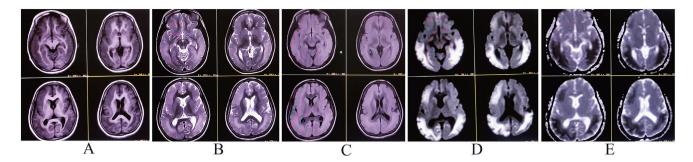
Thick band noted in the subcortical region of bilateral cerebral hemispheres, which is iso to gray matter in all sequences (A-T1, B-T2, C-T2-FLAIR), shows no contrast enhancement and is separated from cortical gray matter and ventricles by white matter—s/o subcortical band heterotropia. The overlying cortex shows broad gyri and shallow sulci, i.e., pachygyria—notice diffusion restriction in bilateral temporoparietal lobes on DWI (D) and ADC (E).
